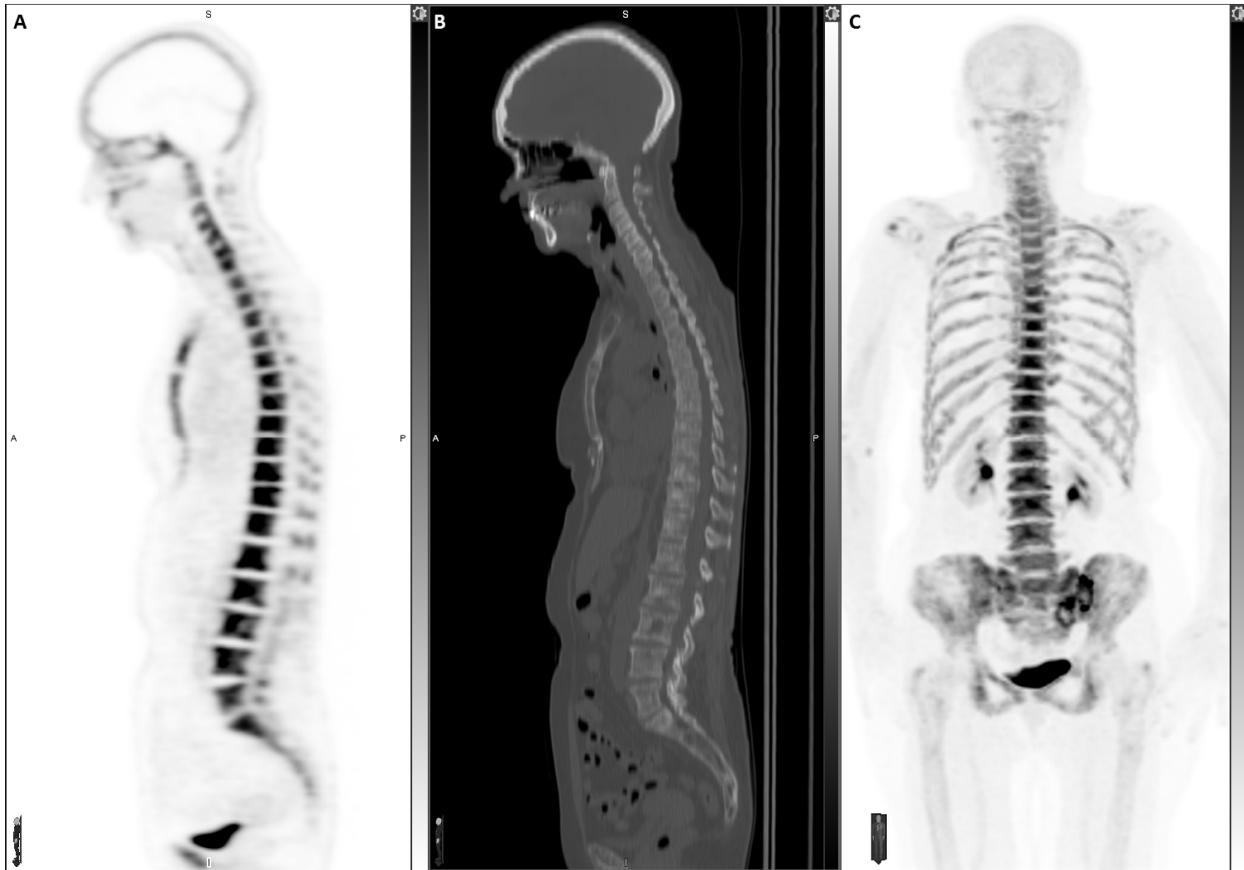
A 81-y-old women with history of metastatic breast cancer. Sagittal views of the (A) ¹⁸F-NaF PET and (B) CT scan and (C) Anterior maximum intensity projection (MIP) view show diffuse sclerotic metastasis to the entire spine, sternum with abnormal increased tracer uptake. MIP image also demonstrate abnormal uptake in the ribs and pelvis.
